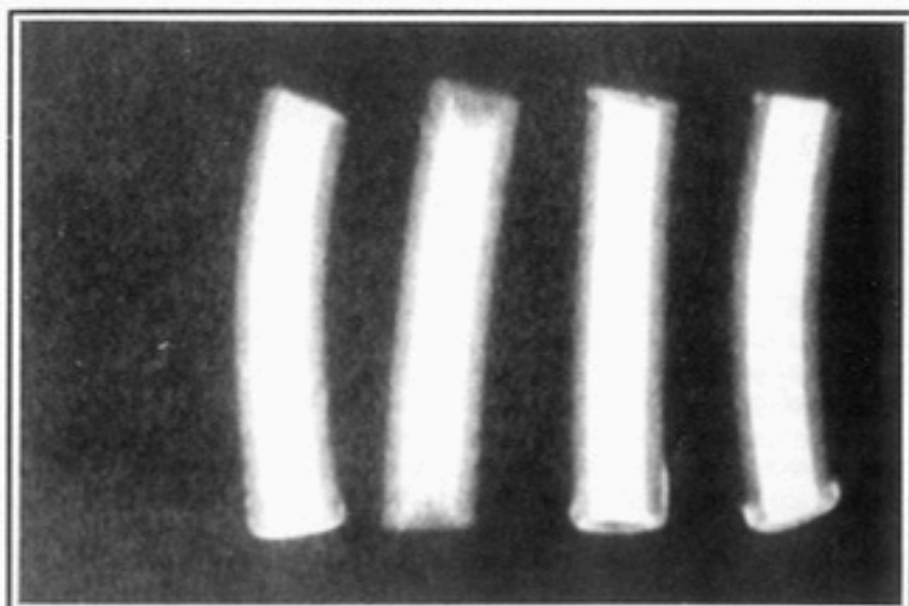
Radiographic evaluation
